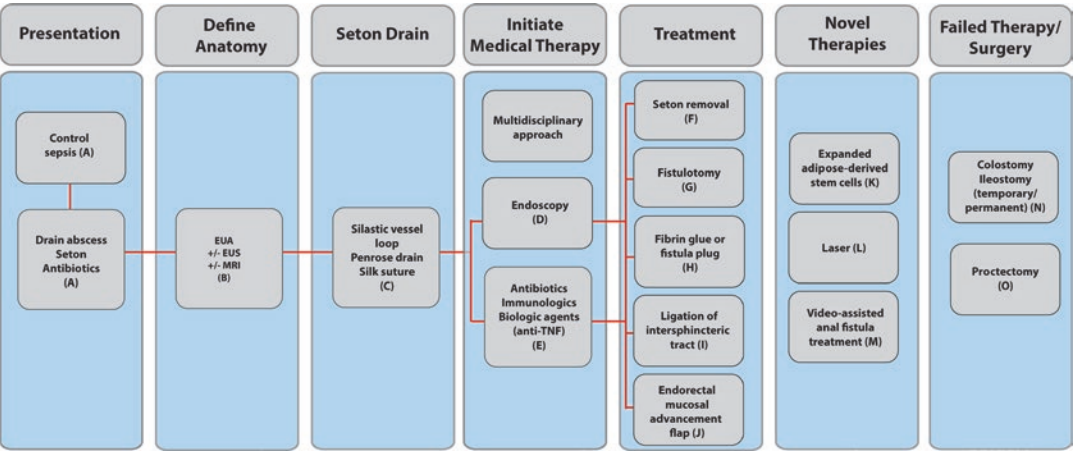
Algorithm for management of an anorectal fistula in Crohn’s disease. *EUA* examination under anesthesia, *EUS* endorectal ultrasound
